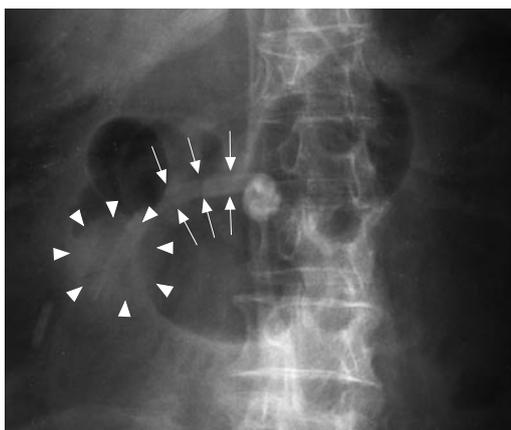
A plain abdominal radiograph showing collected gas in the stomach and duodenum with the tube balloon situated in the second portion of duodenum (tube: arrow, balloon: arrowhead).
